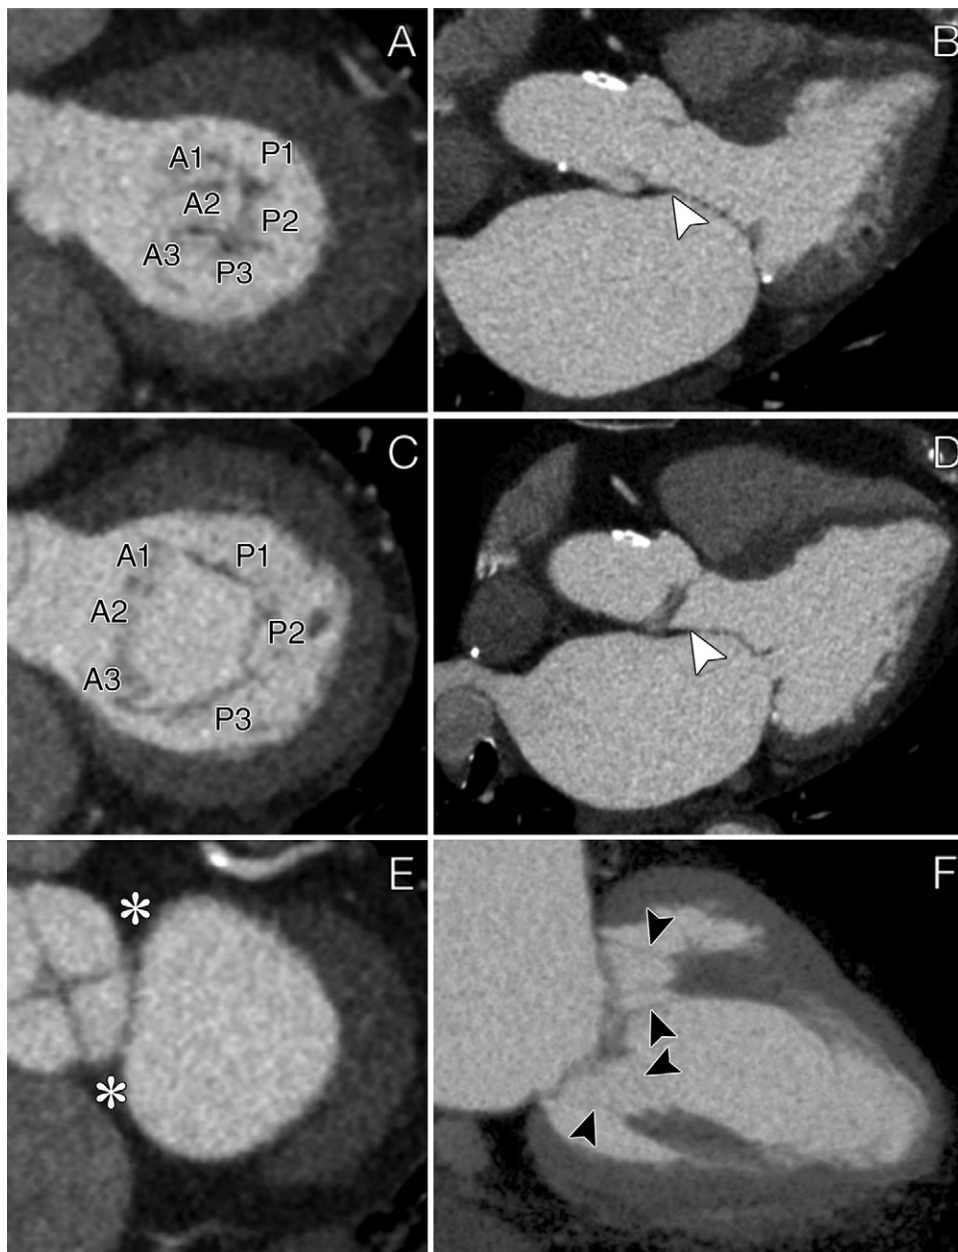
Anatomy of the mitral valve as demonstrated at CT. *A, B*, The mitral valve is closed at end systole. *C, D*, Images show the opened valve at end diastole, with the location of the three scallops of the anterior (A1–A3) and posterior (P1–P3) mitral valve leaflet; arrowhead (*B, D*) highlights the aortomitral continuity forming the anterior horn of the annulus remaining fixed in position throughout the cycle. *E*, Image shows mitral annulus and fibrous trigones (*). *F*, Minimum intensity projection at end systole highlights the complex fan-like radiation of fine tendinae running from the papillary muscles to the mitral leaflets (arrowheads).
